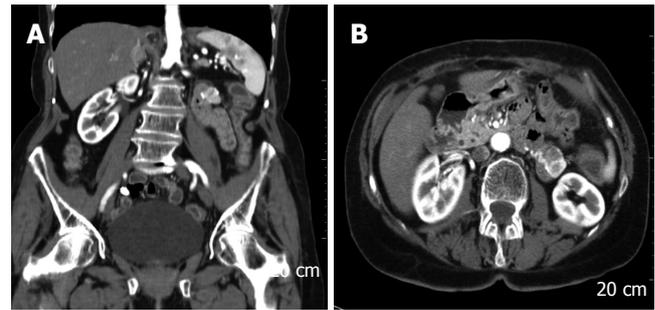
Computed tomography showing the right sided pheochromocytoma (A) and the jejunal GIST (A and B).
